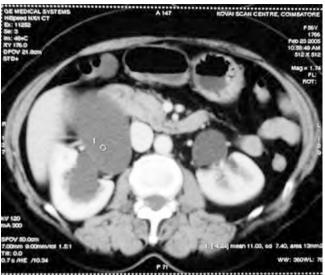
CT image- right UPJ obstruction
